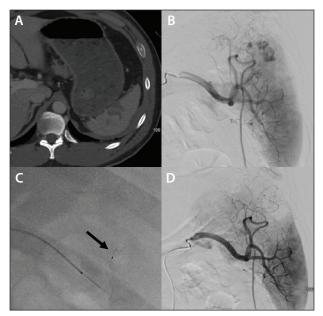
Splenic artery embolization. CT showed a grade IV splenic laceration (A). Angiography demonstrated extravasation in the upper pole of the spleen (B). The feeding vessel was embolized using a single 1.5–4-mm Caterpillar plug (black arrow) (C). Postdeployment angiography demonstrated no flow beyond the plug and no further evidence of extravasation (D).
